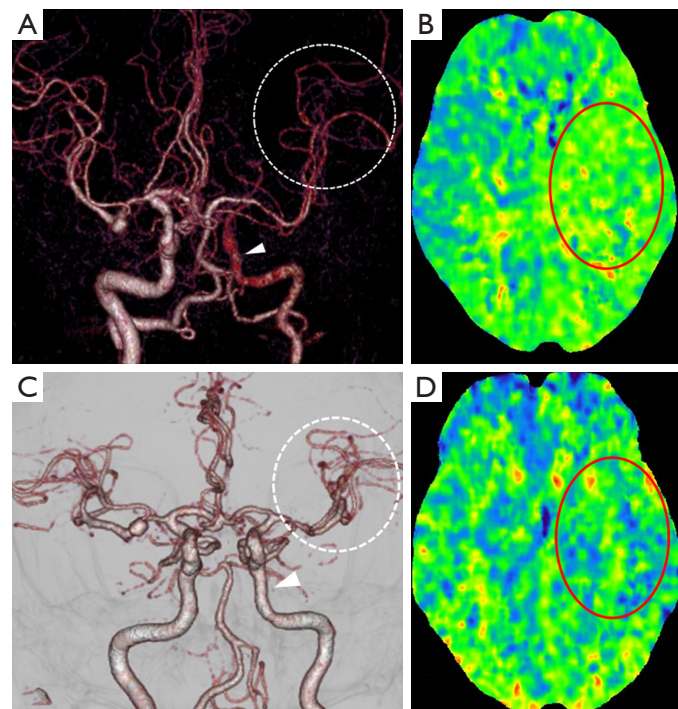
Rile's type 1A left common carotid artery occlusion in a 67-year-old man. (A) In the preoperative head CTA, the arrow indicates the left internal carotid artery and the circle indicates its branches; (B) in the preoperative CTP, the oval indicates the extended MTT; (C) after carotid-carotid crossover bypass, the arrow indicates the left internal carotid artery and the circle indicates its branches in CTA; (D) in the postoperative CTP, the oval indicates the improved MTT. CTA, computed tomography angiography; CTP, computed tomography perfusion; MTT, mean transit time.
